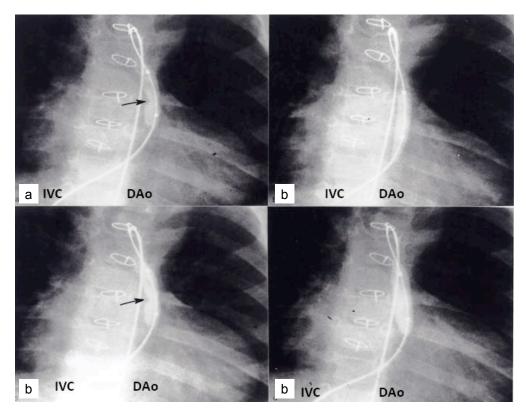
Selected cine-radiographic frames in posteroanterior view showing balloon angioplasty catheters introduced over the femoral venous end of the guide wire and positioned across the atretic but perforated pulmonary valve. Waisting (arrow in a) of the 6 mm balloon is shown which disappeared on further balloon inflation (b). Similar waisting (arrow in c) of the 8 mm balloon is shown which also disappeared on further balloon inflation (d). DAo, descending aorta; IVC, inferior vena cava.
